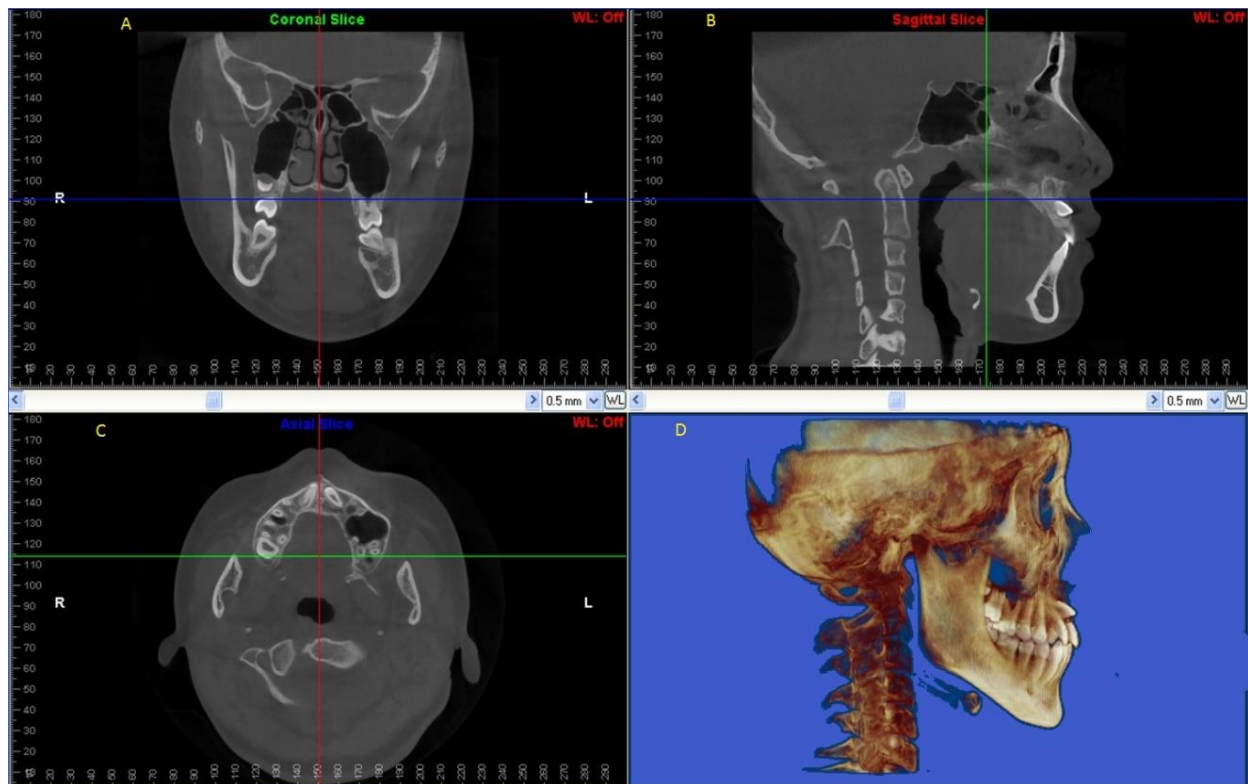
Pre-treatment CBCT scan image of impacted maxillary right lateral incisor in different plans such as coronal, sagittal and axial. (A) Coronal plane and frontal view of the occlusion of the maxillary and mandibular molars and hard tissues in the adjacent region; (B) sagittal plane and lateral view of the impacted maxillary right lateral incisor; (C) axial plane and occlusal view of impacted maxillary right lateral incisor and (D) depicts 3D lateral profile image of the dentition and maxilla-mandibular relationship of patient's right side.
